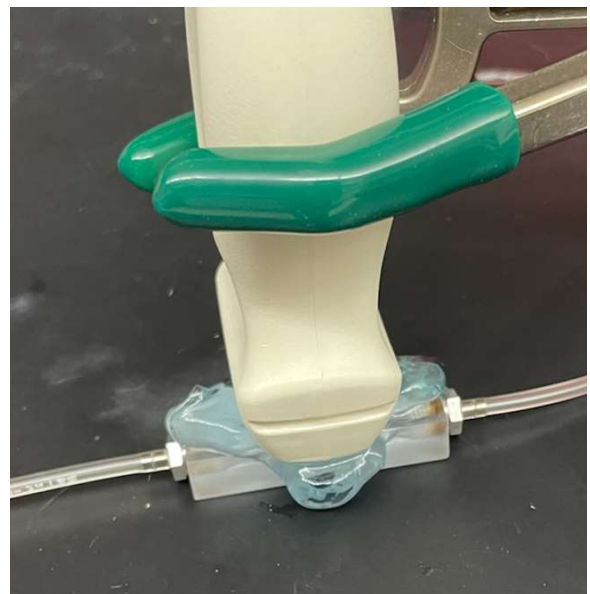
Set-up of 3D printed acoustofluidic device with ultrasound imaging probe.
